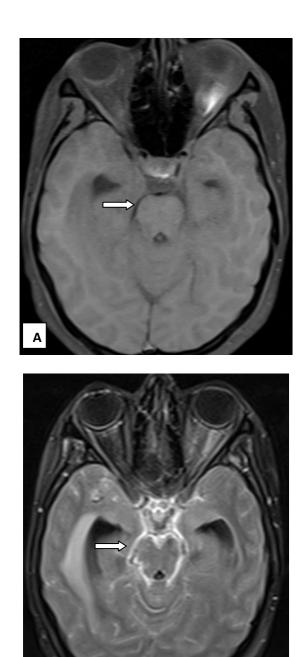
MRI Brain axial sections of 22 years old female with meningoencephalitis. (A) T1 FS PC shows no meningeal enhancement but avid meningeal enhancement is noted on (B) T2 FLAIR PC sequence giving "sugar coated" appearance.
